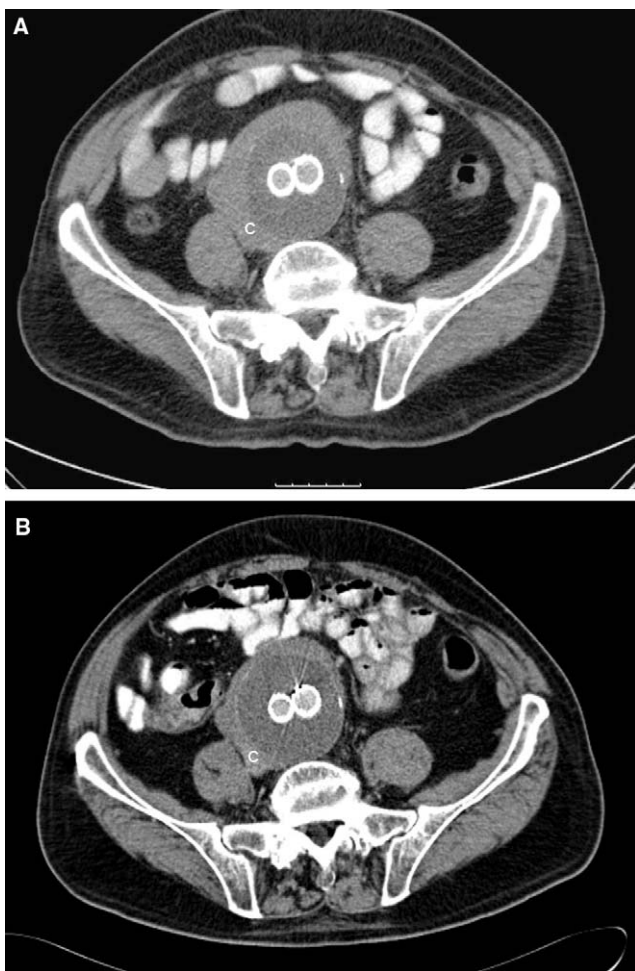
(A) Contrast-enhanced CT scan 14 months post-EVAR in a 76-year-old man shows the two patent limbs of the endovascular graft (Excluder® graft) and a well-delineated peri-aneurysmal soft tissue mass extending to the right psoas muscle. There is some narrowing of the inferior caval vein (C). The posterior aortic wall is spared. (B) A follow-up CT scan after 8 months of treatment with tamoxifen and azathioprine shows regression of the peri-aortic soft tissue mass.
